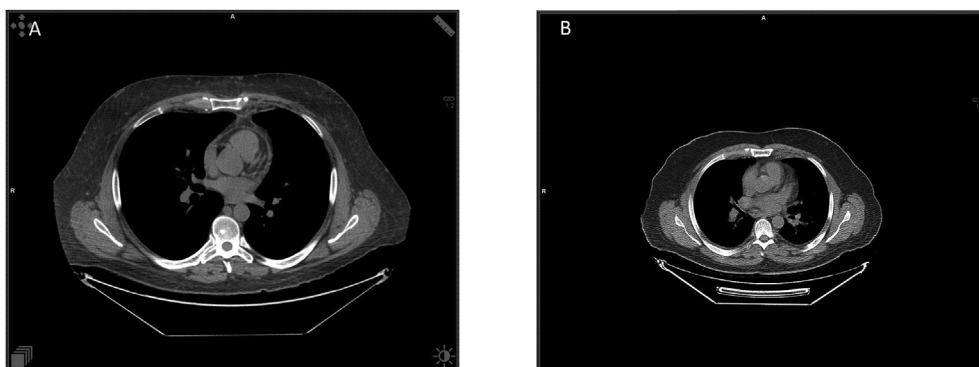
Image comparison between a CAC scan (A) and non-contrast non-gated CT component of a PET study (B) in a patient with lymphoma. This figure demonstrates gated images (A) with improved identification of cardiac substructures in comparison with non-gated CT (B).
